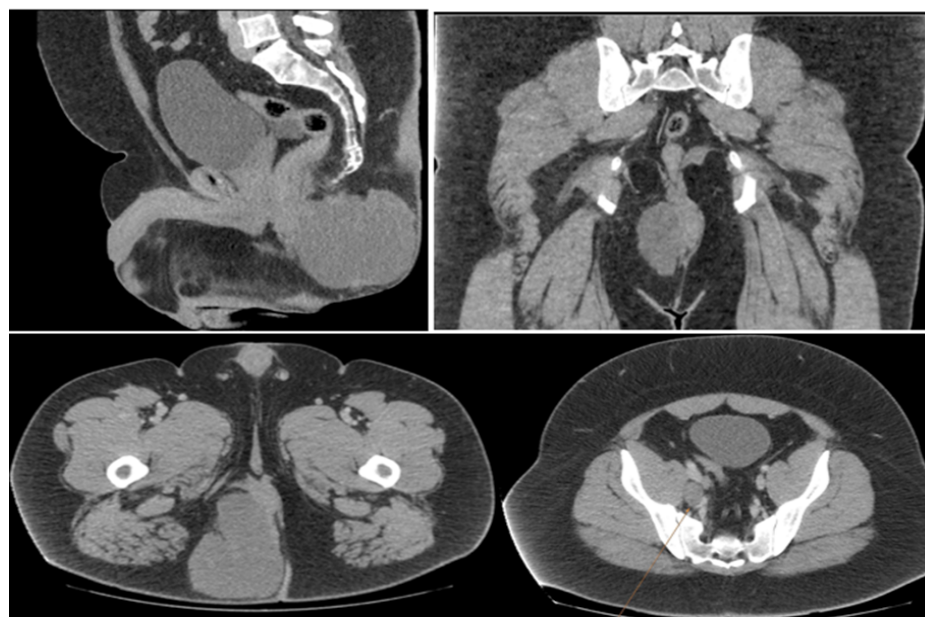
Contrast enhanced computed tomography of the pelvis: sagittal, coronal and axial slices of large hypodense lesion with peripheral enhancement in the right gluteal compartment, accompanied by ipsilateral iliac lymphadenopathy marked with a orange arrow.
